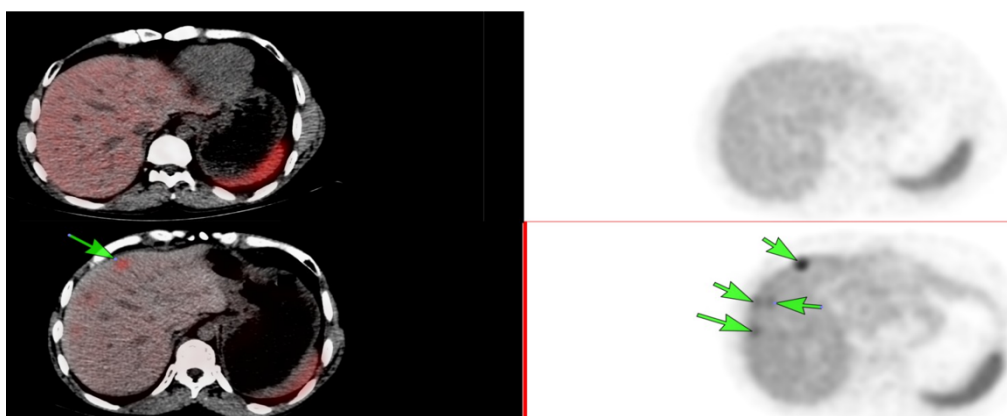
Axial 68Ga-PSMA PET/CT (upper left) and PET (upper right) images and axial 68Ga-DOTATATE PET/CT (lower left) and PET (lower right) images of hepatic metastases. Green arrows denote metastatic foci in the right hepatic lobe. On DOTATATE images, the lesion SUVmax was 16.40 (SUVmean 3.0), indicating intense uptake, whereas PSMA images show only background liver activity (SUVmean 2.50) without focal uptake in metastases, demonstrating lack of PSMA avidity in these lesions.
